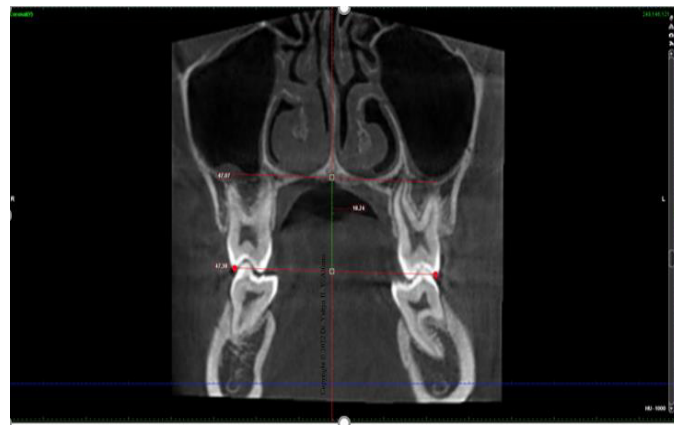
In a coronal view of a CBCT scan, a horizontal line was drawn through the nasal floor perpendicular to the vertical skeletal line to determine the distance between this horizontal line and the bilateral mesiobuccal cusp of the inter first molar width to determine the palatal height measurement.
